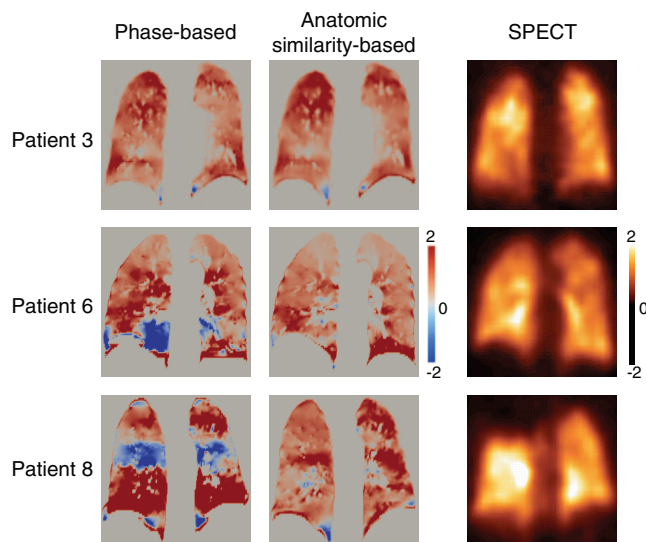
4D CT ventilation images (phase-based and anatomic similarity-based sorting) and SPECT ventilation image for patients 3, 6, and 8. Note that both 4D CT ventilation and SPECT ventilation are normalized by the overall mean value. A positive 4D CT ventilation value represents local expansion, while a negative value represents local contraction. A positive SPECT ventilation value represents local depositions of DTPA aerosols, while a negative value represents no depositions.
